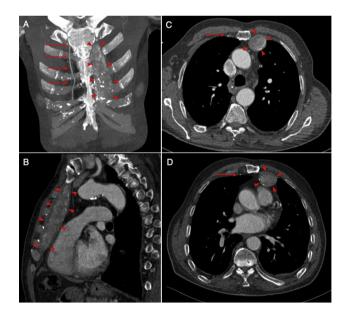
Coronal maximum intensity projection (A), sagittal (B), and consecutive axial (C and D) CT scans in mediastinal window show a thrombosed giant left internal mammary artery aneurysm aneurysm (arrow heads). The right internal mammary artery seen as normal (arrows).
